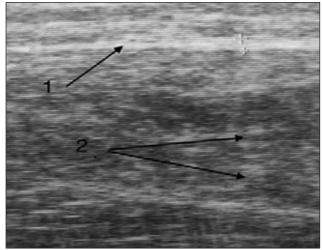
A 13-year-old patient V., diagnosis: cerebral palsy with impaired muscle tone in the form of spasticity. Sonography of the calf muscle: 1 - fascia, diameter - 0.7; 2 - destructured muscle fibers, increased in volume
